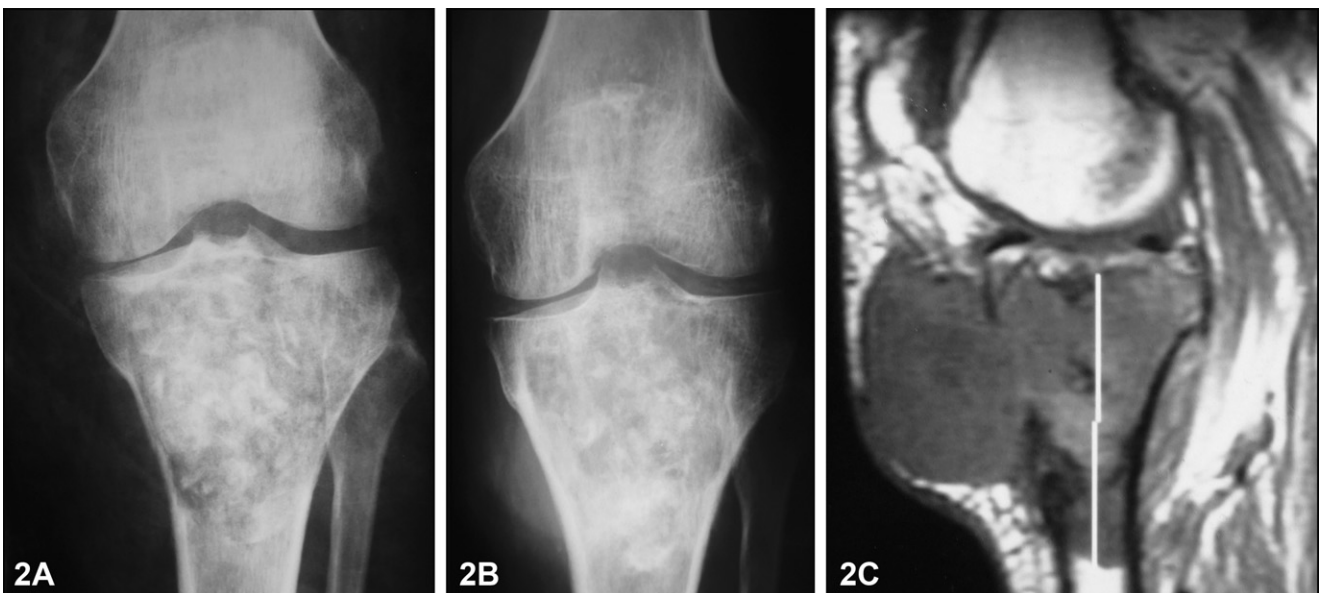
Case 2: (A) Giant cell tumor after curettage and grafting with allograft bone, August 1961. (B) April 1989 (AP radiograph), and (C) (sagittal T1W MR image): massive soft tissue involvement by the osteosarcoma.
